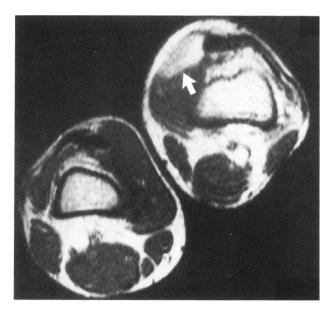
MRI with T2 weighting (SE TR=2000, TE=60) reveals a lesion of the vastus medialis (arrow) which proved to be a hemangioma.
